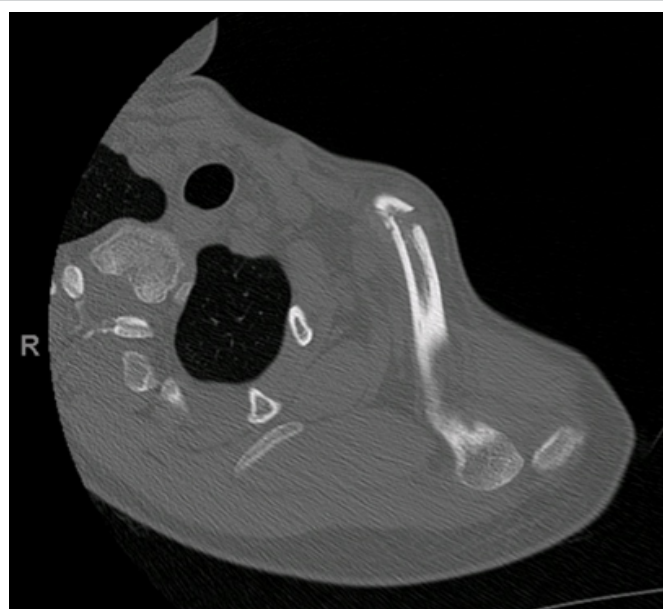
Computed tomography scan with 3D reconstruction, with confirmation of the posterior dislocation of the acromioclavicular joint associated with the medial clavicle fracture.
